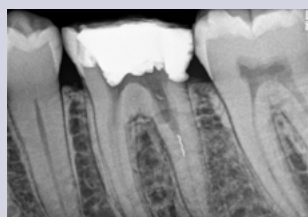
Periapical radiograph of tooth #19 with separated instrument in distal root.
